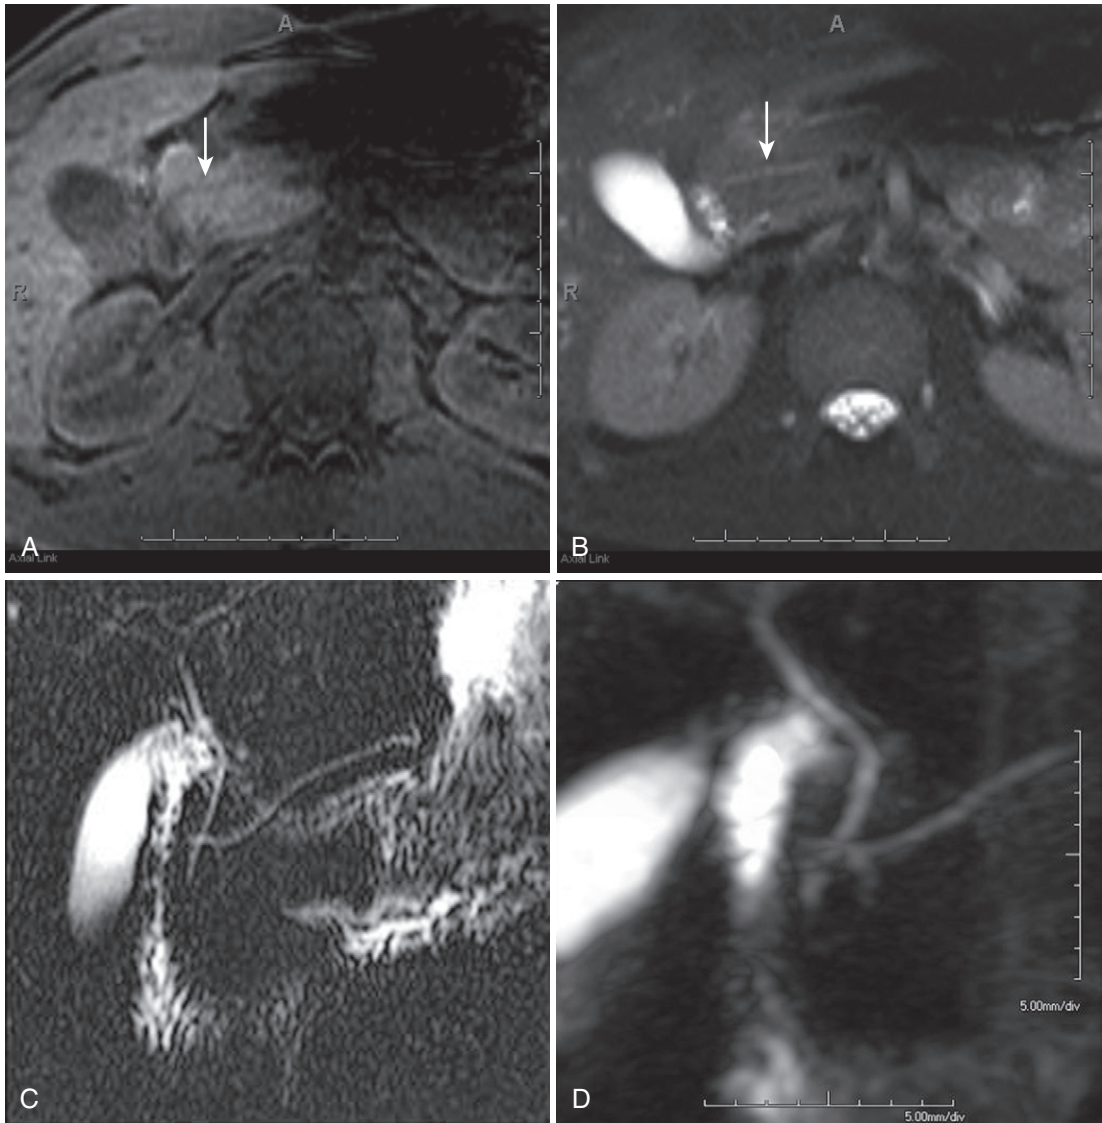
Pancreas divisum. Fat-suppressed T1-weighted gradient recalled-echo (A) and T2-weighted (B) images depict the drainage of the accessory duct of Santorini into the second portion of the duodenum (*arrows*). Thick-slab three-dimensional (3-D) magnetic resonance cholangiopancreatography (MRCP) and coned down views (C and D, respectively) show the classic crossed-duct appearance of the pancreatic accessory duct of Santorini and the common bile duct (CBD).
